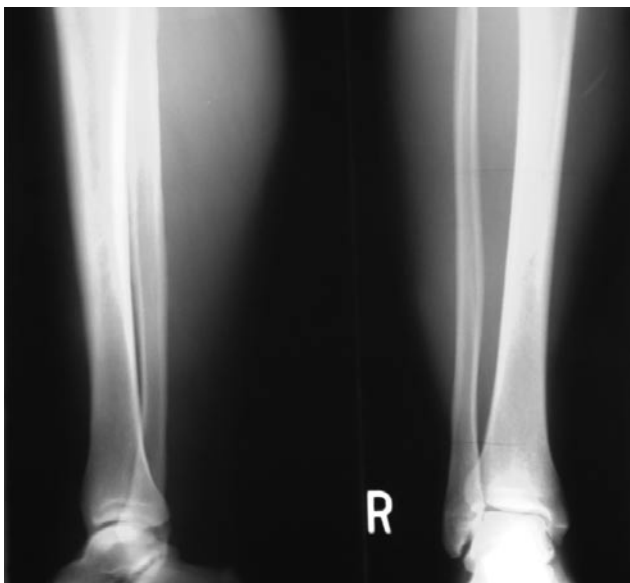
Initial radiographs show no soft-tissue mass, osteoid production, or osseous involvement.
